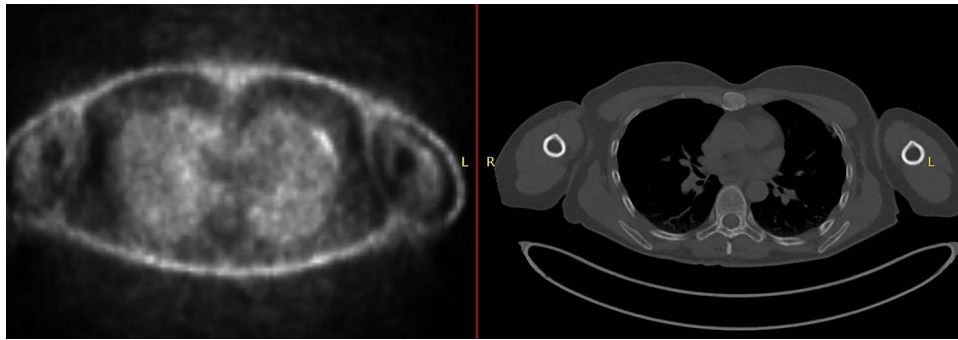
CT-PET demonstrating increased metabolic activity within the sternal lesion.
